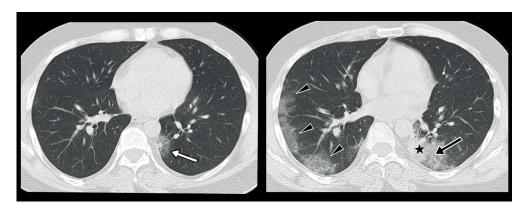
A 37-year-old male patient: Initial chest CT demonstrates a small nodule with a peripheral ground-glass density area in the left lung (white arrow); halo sign. Follow-up chest CT demonstrates the progression of the findings including peripheral ground-glass areas in the right lung (arrowheads), consolidation (asterisk) and air bronchogram (black arrow) in the left lung.
